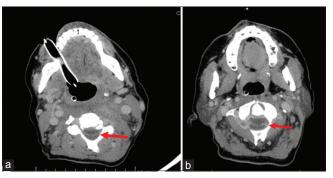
(a and b) Axial computed tomography cervical spine showing a cervical epidural abscess
